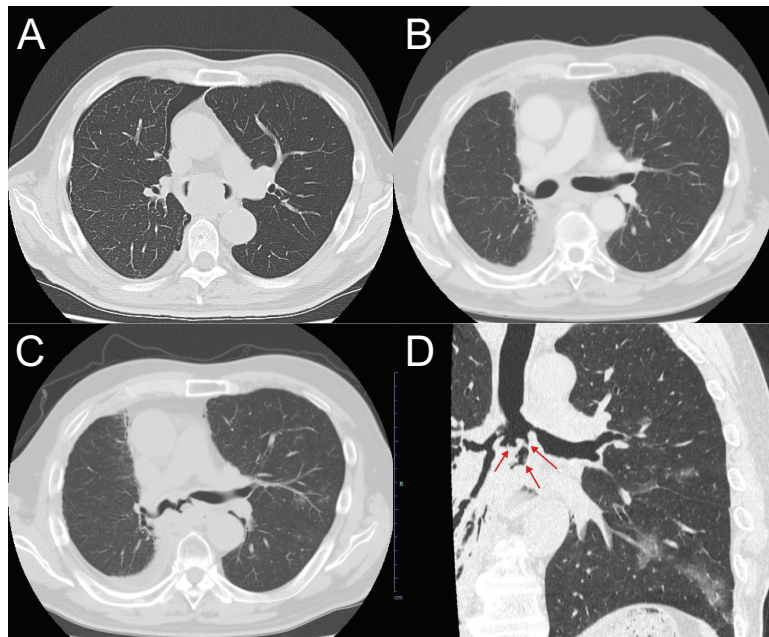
Serial chest CT images showing tumour regression and recurrence. (A) Initial CT at diagnosis showing tumour invasion into the carina, nearly obstructing both main bronchi. (B) Post-treatment CT after chemoradiotherapy and durvalumab showing marked tumour regression. (C) CT obtained 10 months later demonstrating rapid regrowth of subcarinal lymph nodes and invasion into the carina and left main bronchus, resulting in bronchomediastinal fistulization. (D) Coronal CT image corresponding to (C). Arrows indicate fistulas.
